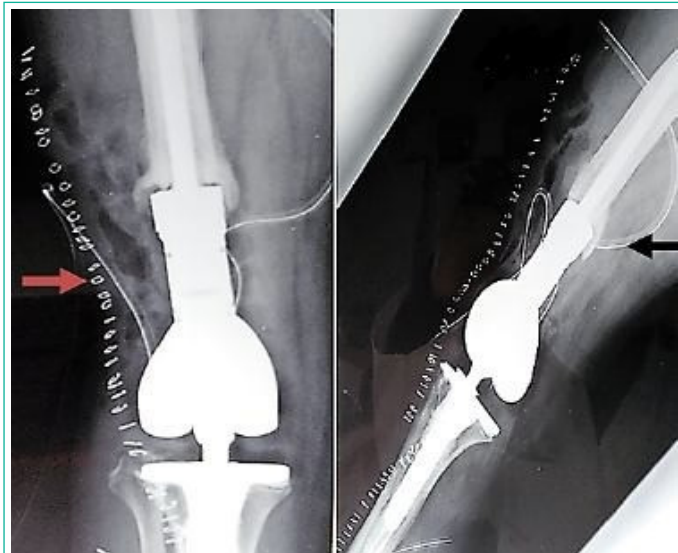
Control X-ray of the right knee seen from the front and from the side after the placement of the chondrosarcoma mega-prosthesis.
